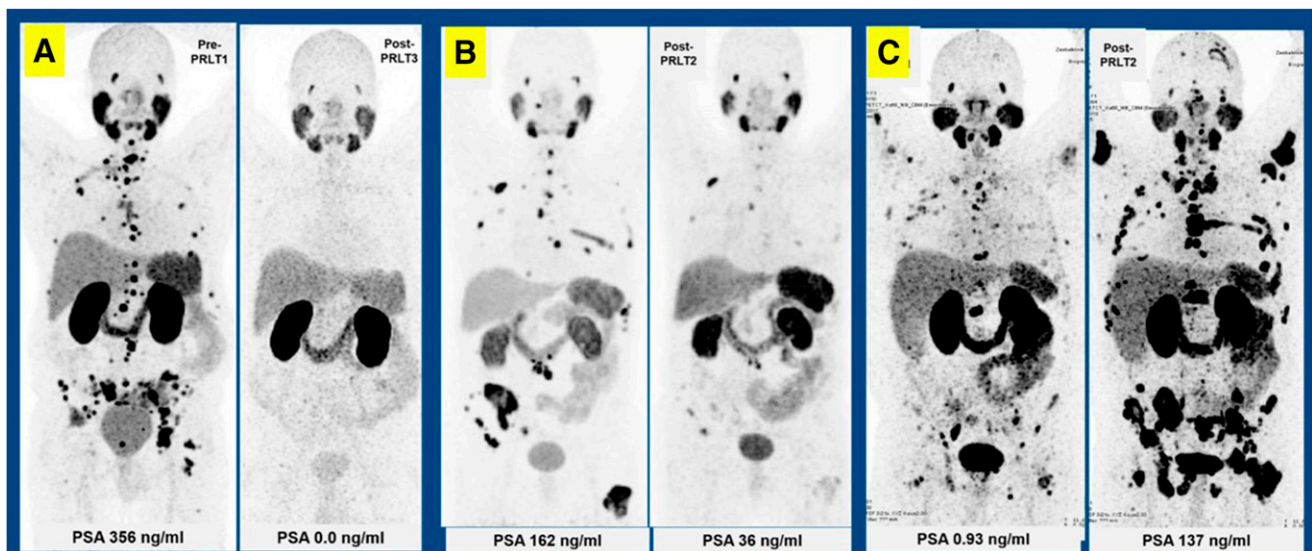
Germline gene variants and therapy response in patients referred for radioligand therapy with ^{177}Lu -PSMA. Examples in patients with: (A) CHEK2 mutation showing complete response; (B) BRCA2 mutation with partial response; (C) and BRCA1 mutation with progressive disease following ^{177}Lu -PSMA therapy.
